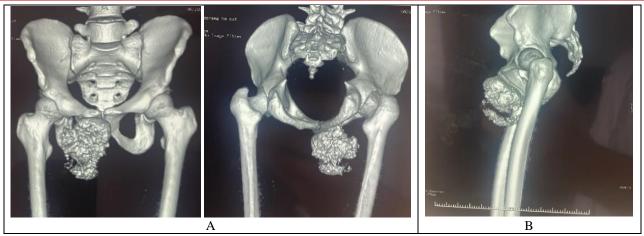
3D computed tomography scan. AP view (A) and lateral view (B)
